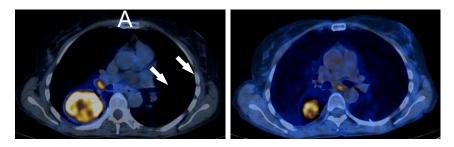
Large cell carcinoma in a 66-year-old patient. (A) A baseline 18F-FDG PET/CT image reveals hypermetabolic tumor mass in the right lower lobe associated with ipsi-lateral mediastinal lymph node metastasis (arrows). (B) Post-chemotherapy PET/CT displays significant reduction in both the 18F-FDG uptake as well as the size of the tumoral mass (arrow) along with a complete disappearence of the metastatic lymph node. Please note that the newly appearing focal hot spot (arrow head) was correctly identified by PET/CT to be the expression of a reflux oesophagitis and not of a cancer spread to the subcarinal nodal station.
